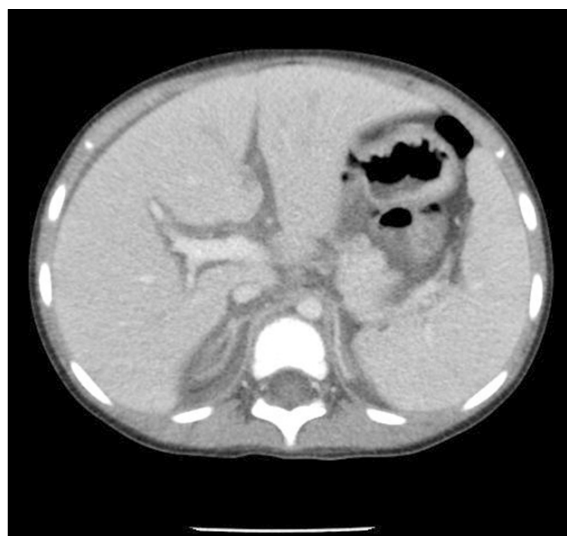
Contrast-enhanced abdominal computed tomography in a boy with enteric adenovirus-induced hemophagocytic lymphohistiocytosis. There was edema of the periportal area, pericystic area, gallbladder, and whole bowel area. Splenomegaly and minimal ascites were also found.
